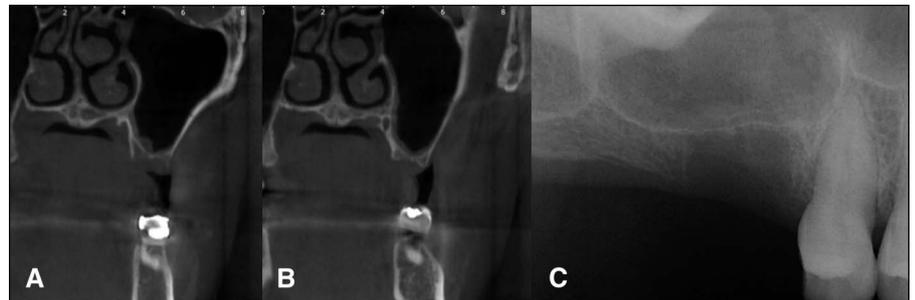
The axial aspect of preoperative CBCT and periapical radiogram. A, Right first molar showing approximately 0.5-mm residual bone height. B, Right second molar showing approximately 1-mm residual bone height. C, Periapical radiogram displays a septa on the right maxillary sinus.
